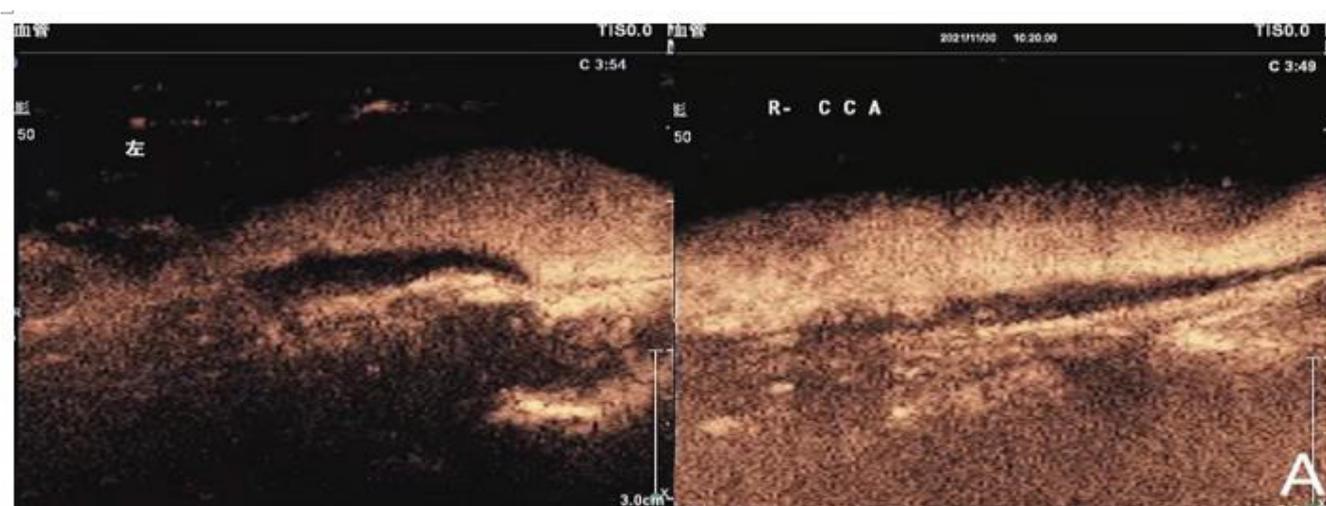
CEUS: (Level 0) Plaque on the distal anterior wall of the left common carotid artery (Left of A) and plaque on the posterior wall of the distal segment of the right common carotid artery(right of A) were no microbubbles of ultrasound contrast agent were found.
